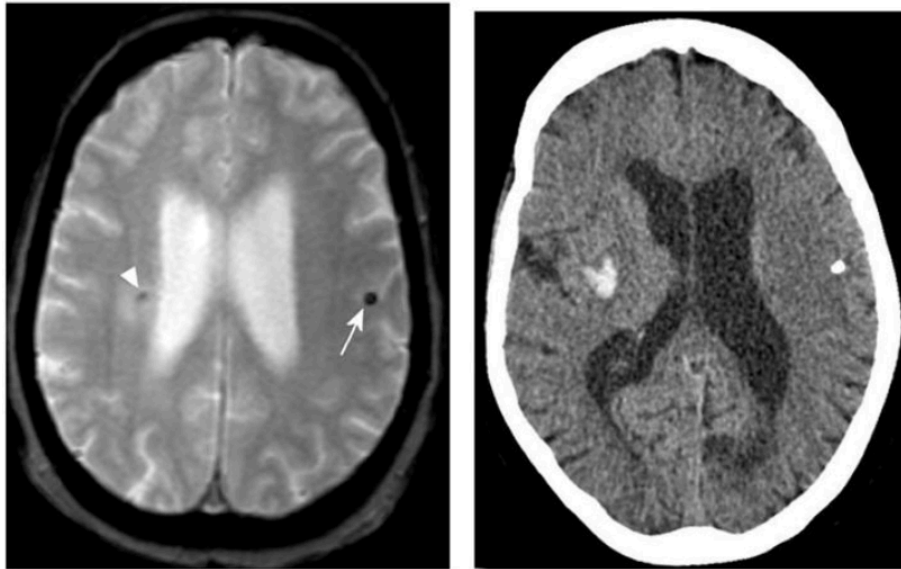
Left: Axial T2-weighted MRI with calcification in left hemisphere mimicking a CMB (arrow). Right: CT scan showing a high-density lesion and a right hemisphere hemorrhage (arrowhead).
